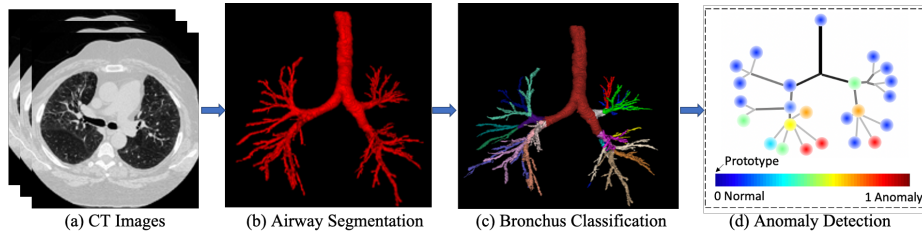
A typical process of the airway-related CAD system. The airway is first segmented from the CT images. Then the bronchus are classified according to the anatomical structure. Finally, our proposed anomaly detection algorithm processes the graph-based classification result and estimates the anomaly at each node.
